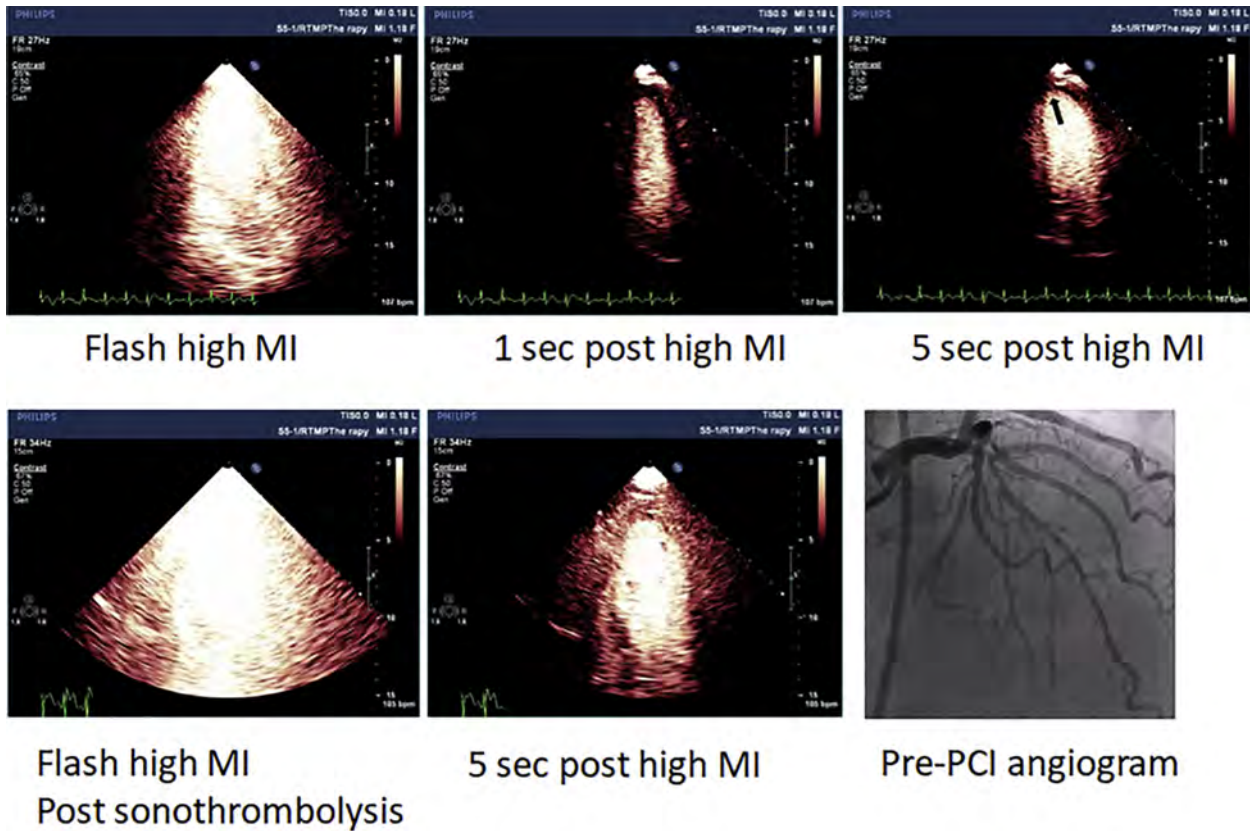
A patient with an anterior STEMI treated with repeated high-MI diagnostic impulses during a dilute UEA infusion before percutaneous coronary intervention (PCI). The *top row* depicts apical microvascular obstruction (*arrow*) in the apical two-chamber view on the initial images obtained as the patient arrived to the ED. A brief (10- to 20-min) period of intermittent high-MI impulses was applied in each apical view during UEA infusion before reaching the cardiac catheterization laboratory, resulting in resolution of the apical defect (*lower row, middle panel*) and angiographic recanalization on the initial projections obtained before stent placement in the left anterior descending coronary artery (*bottom row, right panel*).
